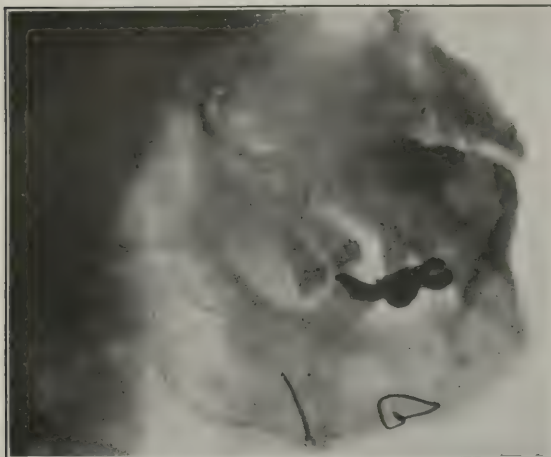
Case 10: Radiograph eight months after operation, showing still further consolidation.
